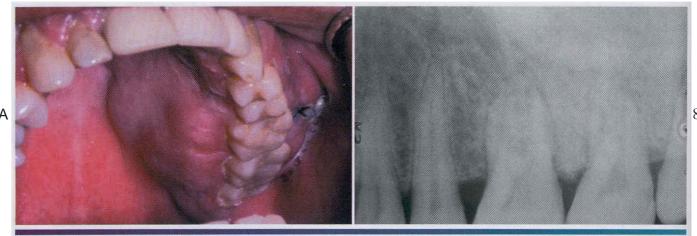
\circ Osteosarcoma. A, This patient shows a firm, painful swelling of the left maxilla of recent onset. B, The periapical radiograph shows a dense sclerotic change in the bone pattern. (Courtesy of Dr. len Morrow.)
